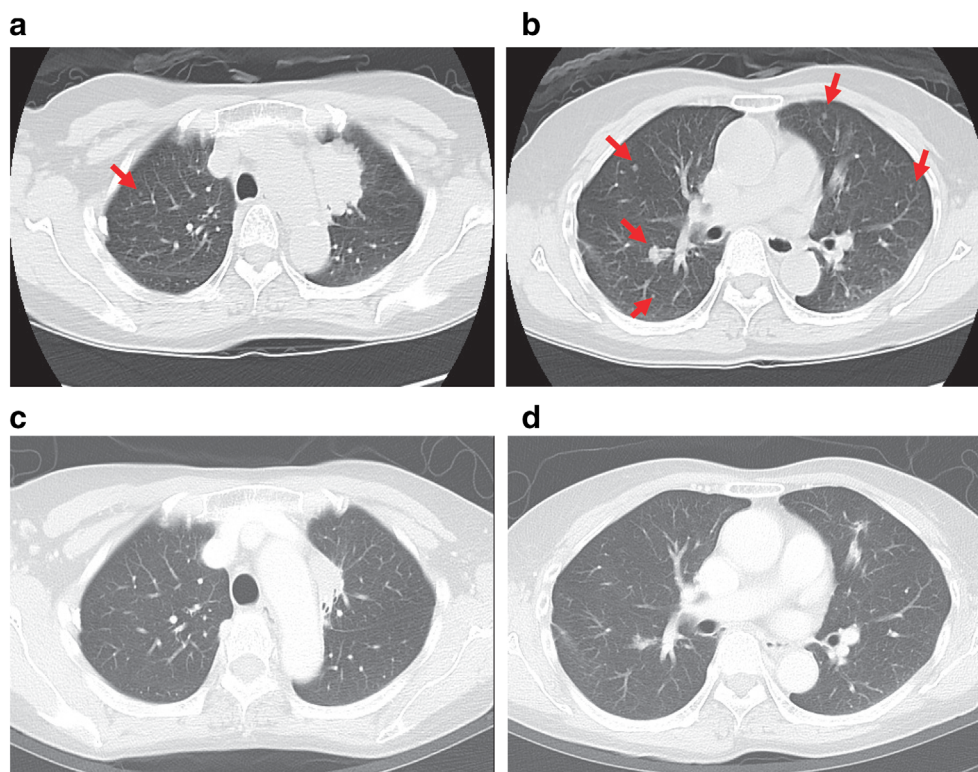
A 67-year-old female patient who had *EGFR*-mutant lung cancer (exon 19 deletion/21 L858R T4N2M1a stage IVA) and underwent targeted therapy with afatinib. (a, b) CT scans: A left upper lobe tumor with multiple lung-to-lung metastases (red arrows); (c, d) CT scans: Shrinkage of main tumor and disappearance of all the lung-to-lung metastases. The patient underwent a left upper lobe (LUL) lobectomy and mediastinal lymph node dissection. The patient remains under *EGFR*-TKI treatment and is free of disease recurrence 36 months after undergoing surgery.
